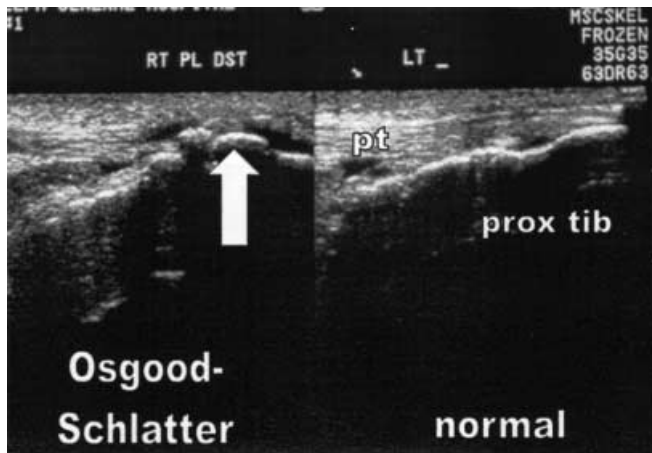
Osgood-Schlatter disease. At the late stage, ultrasound can document bony fragmentation (*left*). Compare with the normal appearance (*right*)
